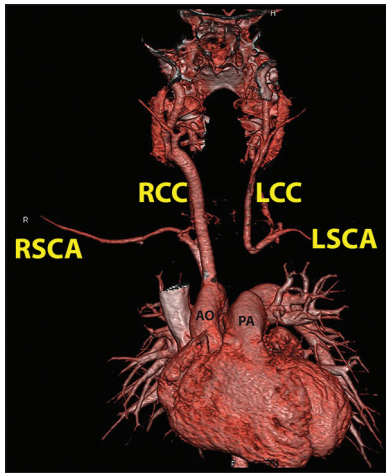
Three-dimensional, volume -rendered image of computed tomographic angiography shows the right aortic arch with isolation of the left brachiocephalic artery. LCC artery is smaller than RCC artery. The distance between the isolated left brachiocephalic artery with the aortic arch is significant. RCC: Right common carotid; LCC: Left common carotid, RSCA: Right subclavian artery, LSCA: Left subclavian artery, AO: Aorta, PA: Pulmonary artery
